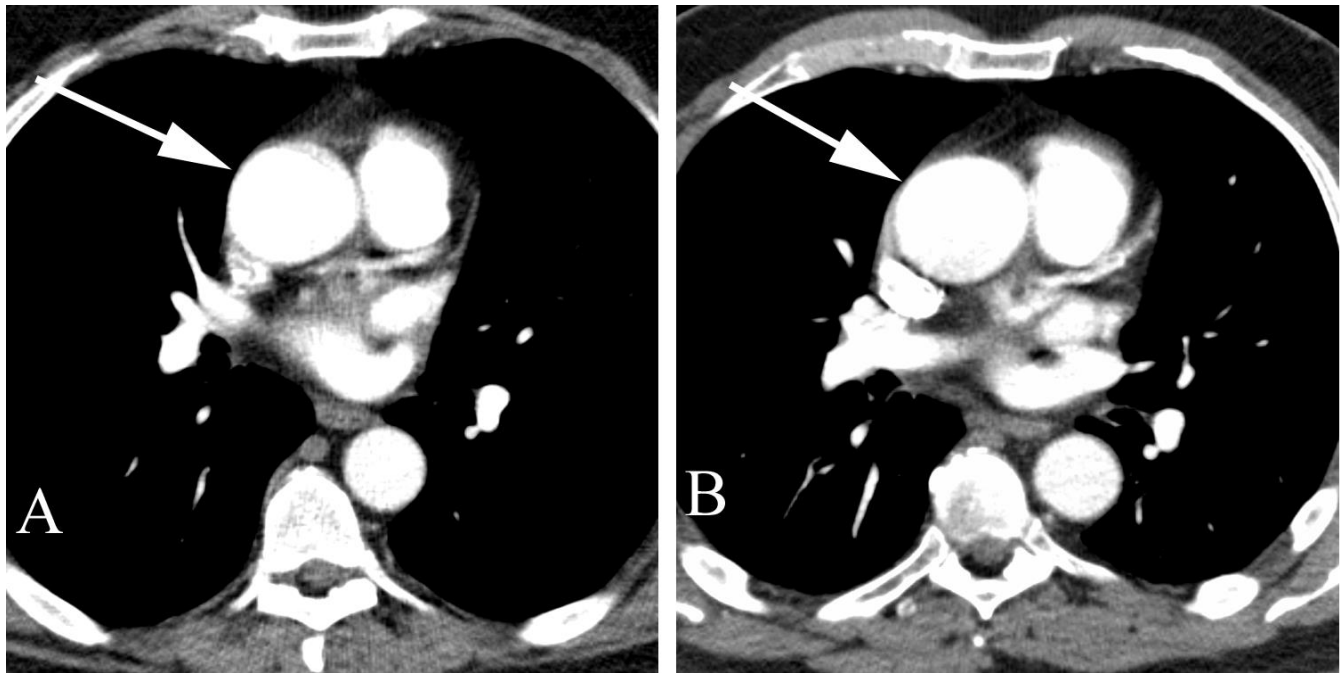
Stable thoracic aortic aneurysm in a 67 year old man with a known thoracic aortic aneurysm. A. Axial contrast-enhanced chest CT shows a thoracic aortic aneurysm which measured 51 mm. Annual studies were performed in follow-up. B. Axial contrast-enhanced chest CT done three years later shows an identical appearance and measurement. Interval annual studies (not shown) showed similar results.
